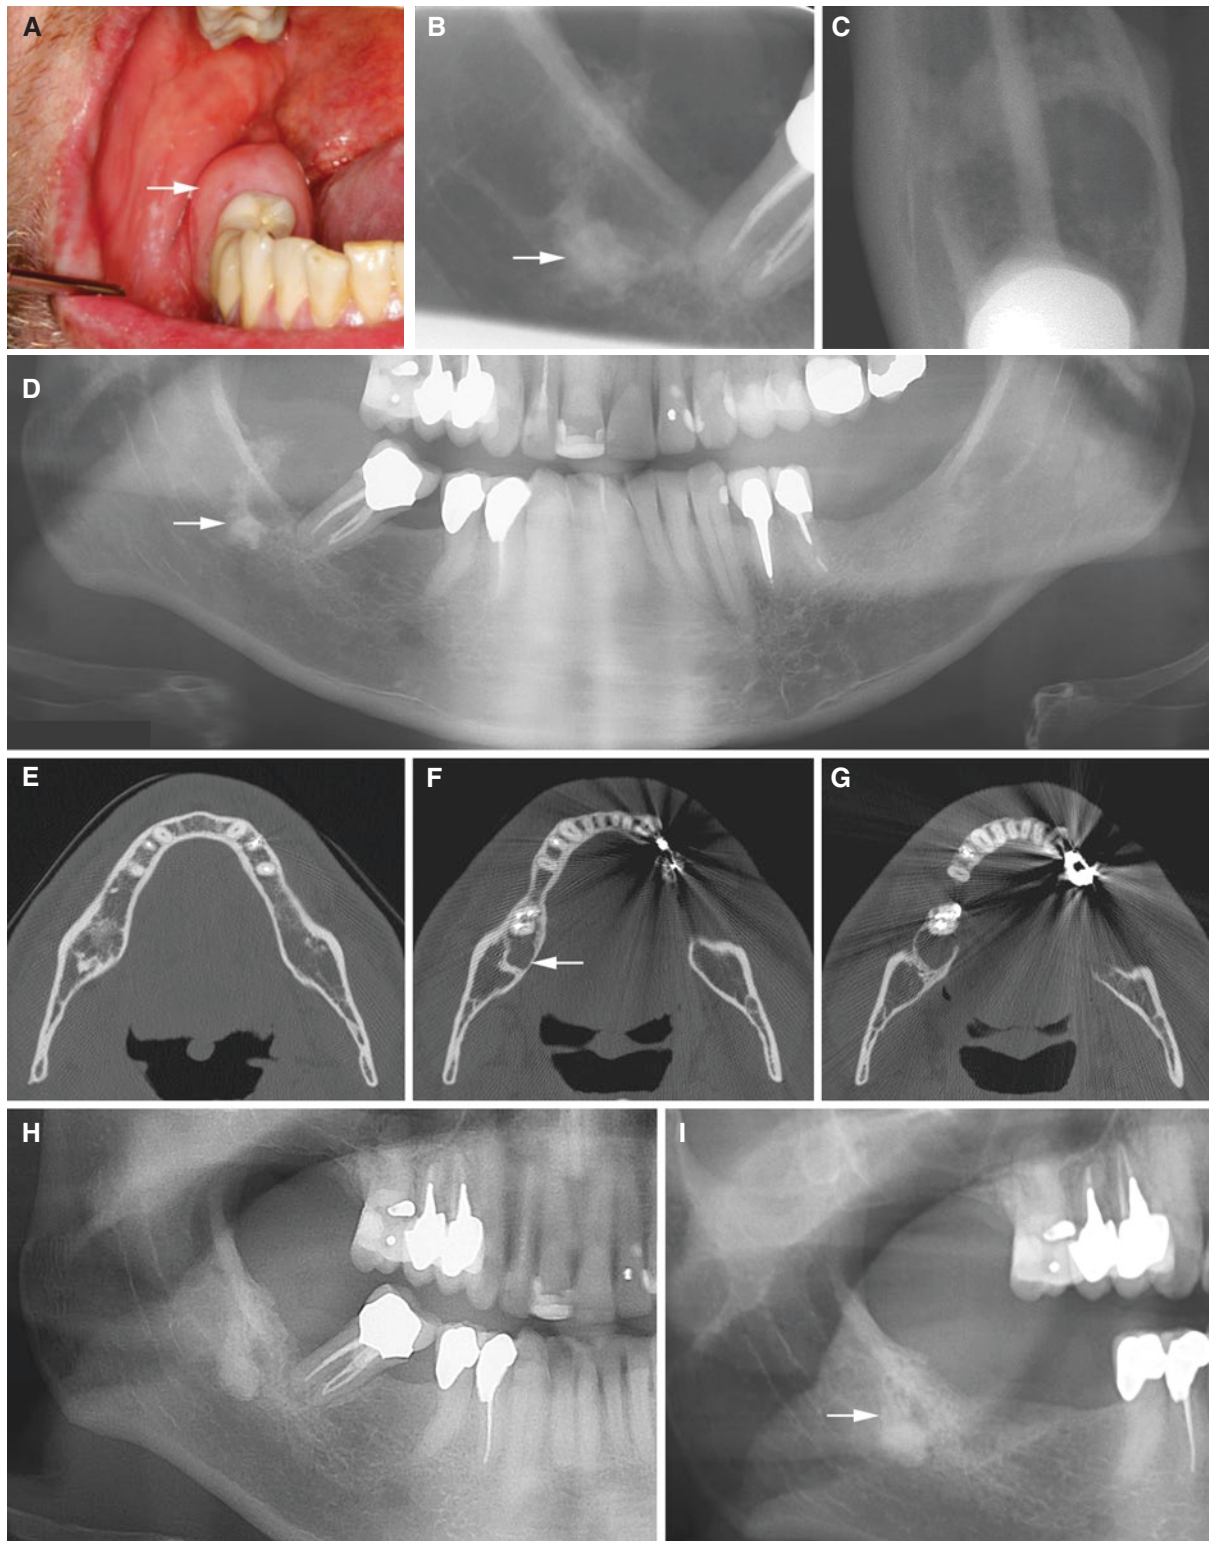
Ameloblastoma, desmoplastic, mandible; 40-year-old male with pain-free swelling of the gingiva in the right mandible posterior to the remaining molar. (A) Clinical photograph shows gingival mass with normal mucosa (*arrow*). (B) Intraoral (periapical), (C) occlusal (axial), and (D) panoramic views show radiolucency with sclerotic margins
